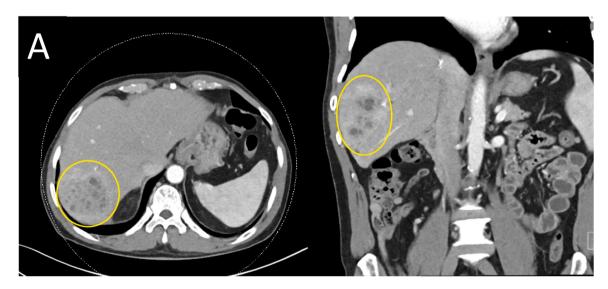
A CT scan of the abdomen with intravenous contrast showing 9 cm loculated hepatic abscess, highlighted by yellow circle.
